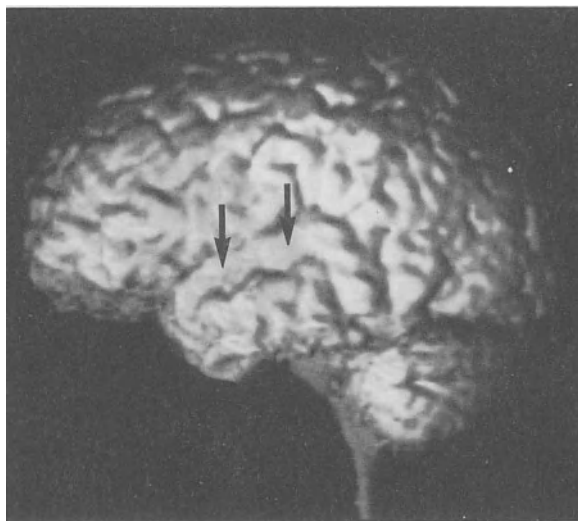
Three-dimensional view of the brain surface created by volume-rendering a stack of edited MR images, including the one in Fig 2c. No anatomic abnormalities are evident; there is good visualization of the superior temporal gyrus (arrows), which is associated with hearing.
